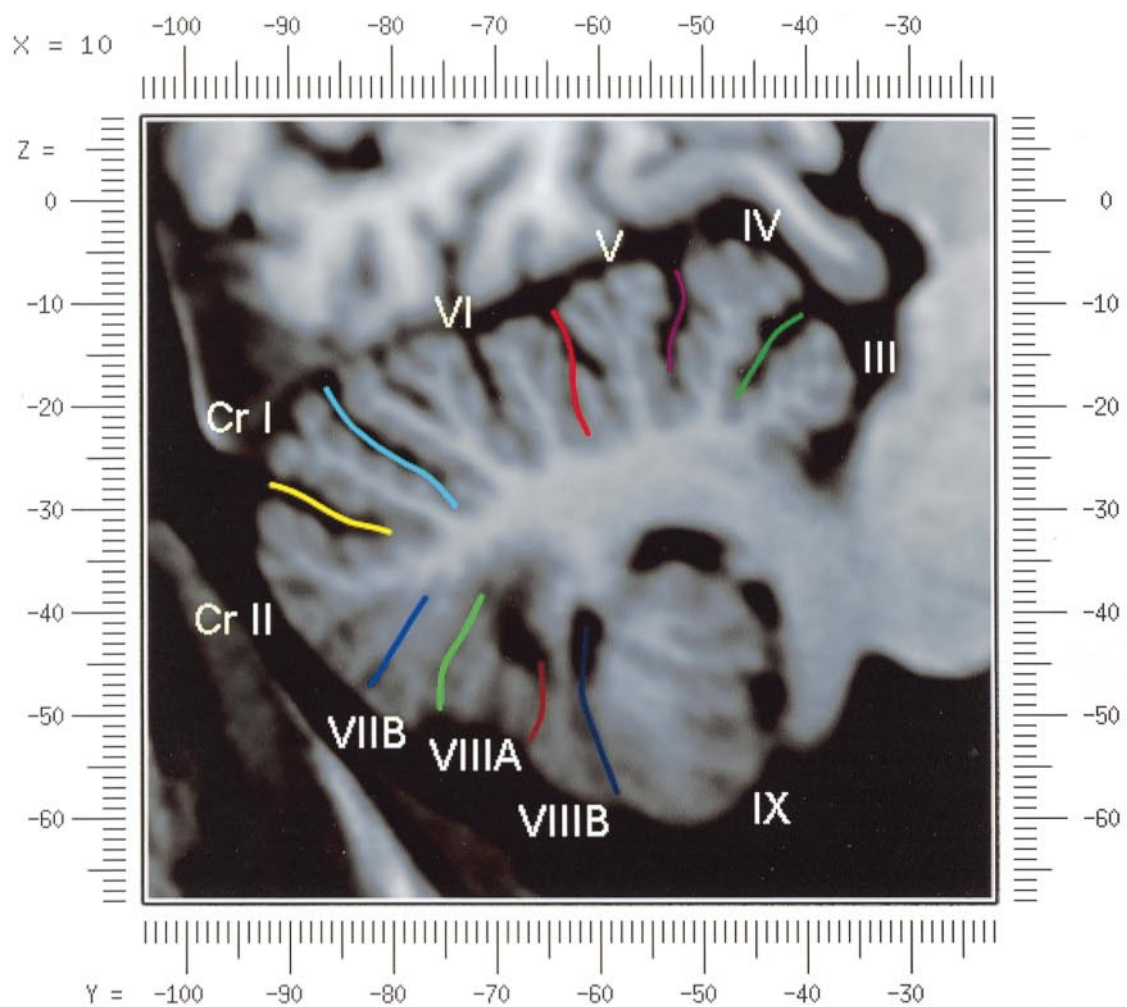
Top: Sagittal MRI image of the cerebellum 10 mm to the right of midline. Bottom: A postmortem cryosection of another human cerebellum in the sagittal plane prepared according to the method of Toga et al. (1997), corresponding to $x = +10$ mm. D, dentate nucleus.
